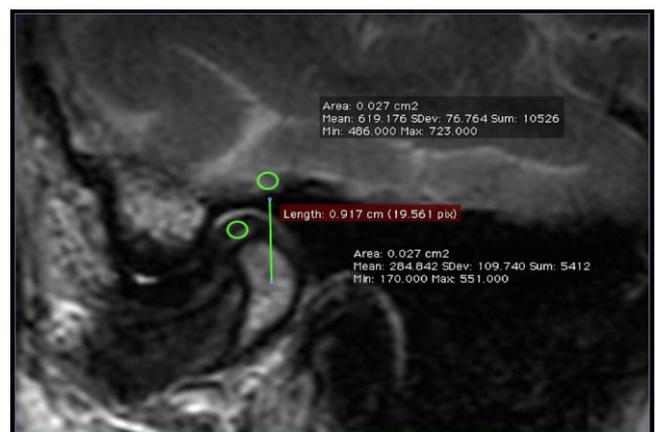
MRI: sagittal plane, T2-weighted image. The ROI selection at retrodiskal tissue and gray matter.
